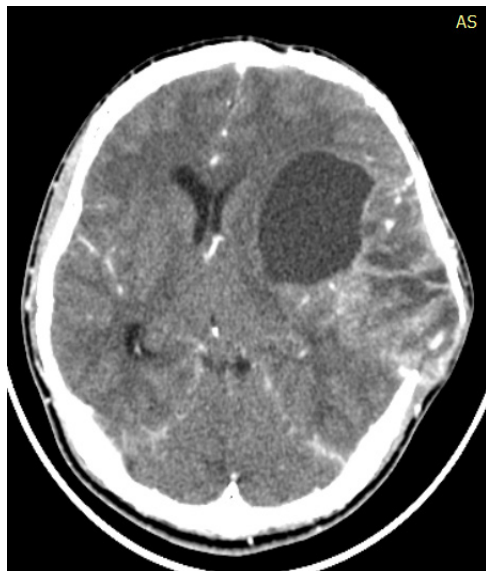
Contrast-enhanced computed tomography (CECT) brain
